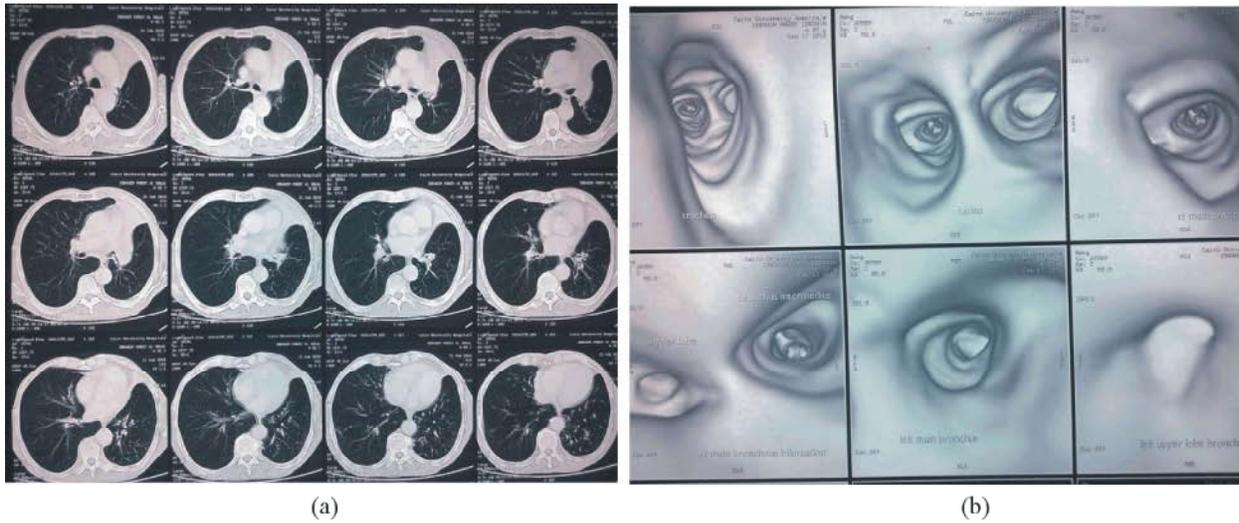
(a) CT chest shows left hilar mass lesion. (b) VB shows obstructed left upper lobe bronchus.
